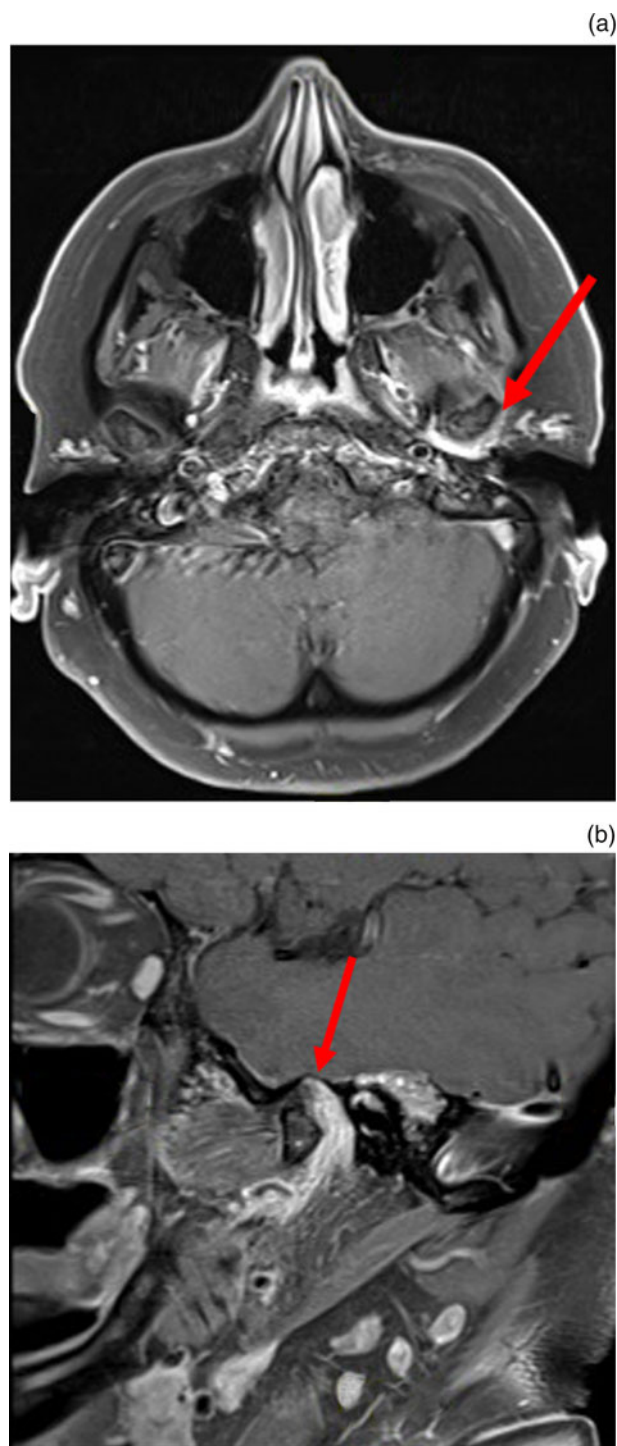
(a) Axial and (b) sagittal views of inflammatory phlegmon in left condylar fossa (red arrows) on contrast-enhanced T1-weighted magnetic resonance imaging scans.
